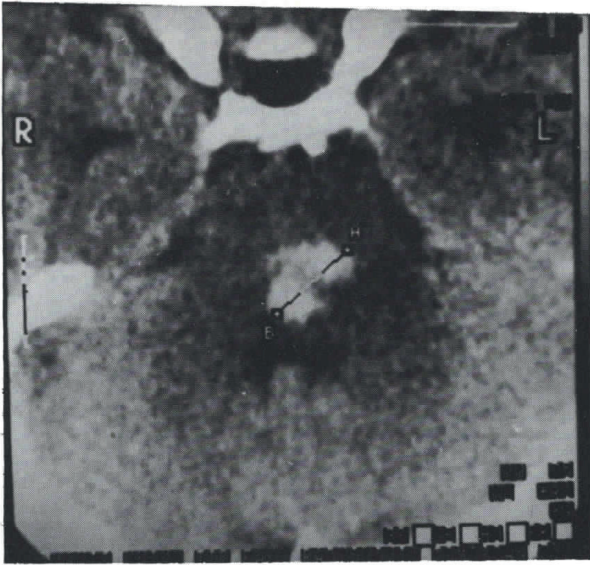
CT scanning showing pontine high density lesion rostral to the fourth ventricle.
